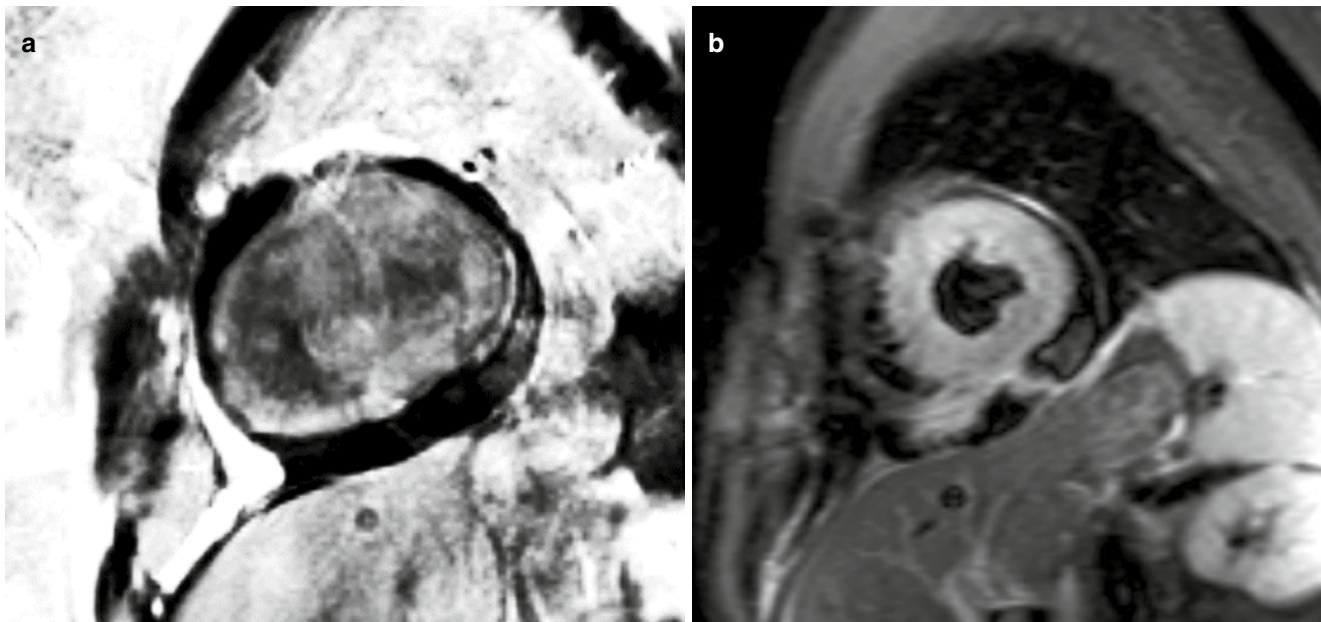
MR images in acute myocarditis. (a) Post-contrast MR image shows strong enhancement of the LV wall on the early phase of Gd enhancement. (b) STIR image shows high signal intensity in the entire myocardium due to diffuse myocardial edema
